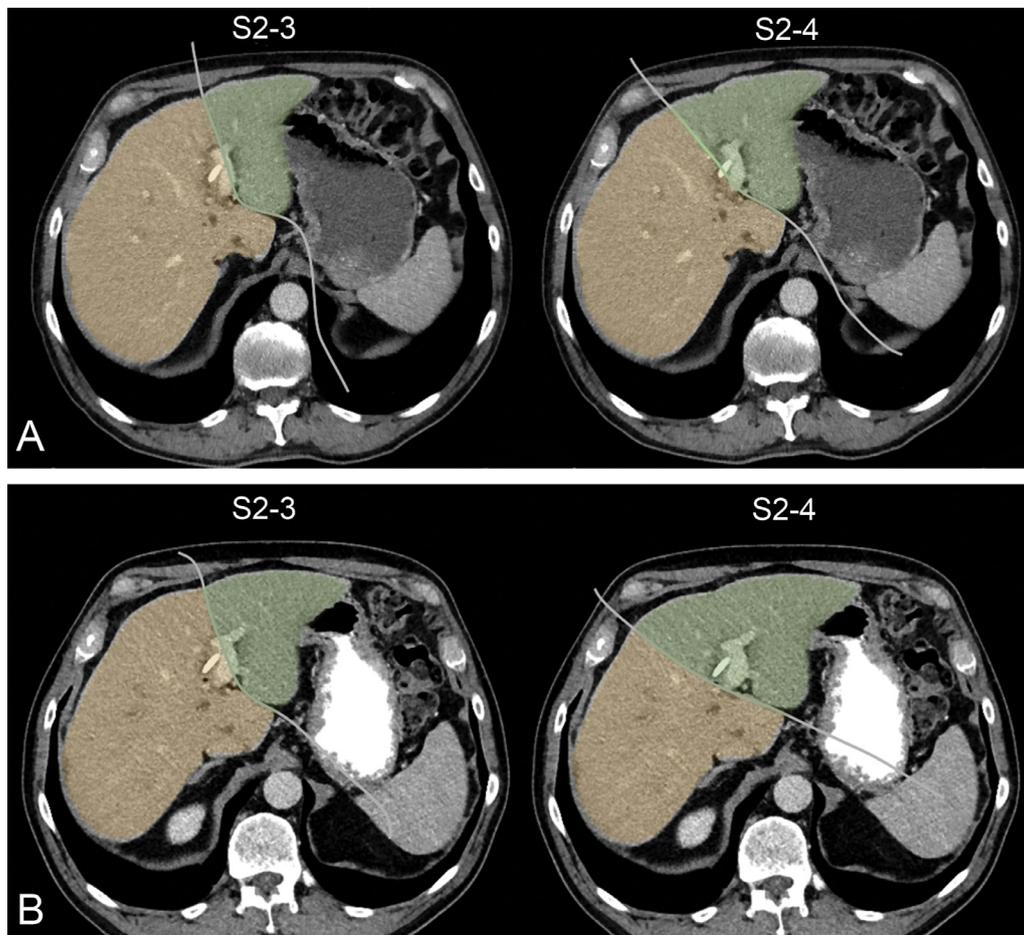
CT-volumetry, delineation of S2-3 + S2-4, pre-PVE and post-PVE.
